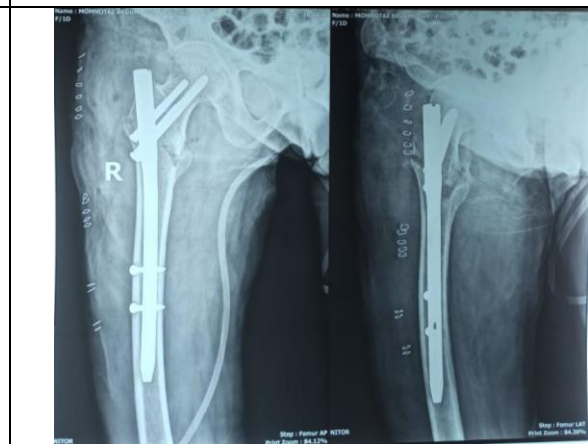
Immediate post operative X-ray by PFN
